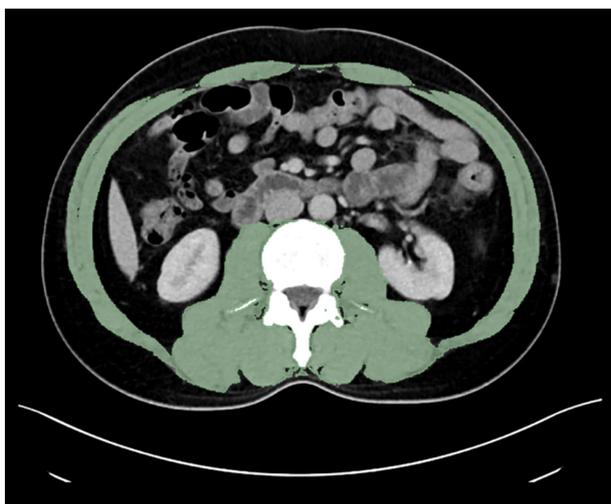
Example of a computed tomography image used for skeletal muscle measurements.
